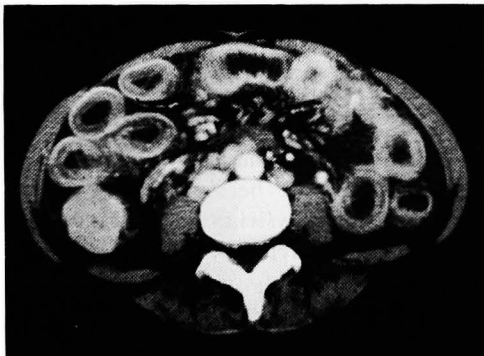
Retention of ascitic fluid and thickening of the intestinal walls were visualized on CT. Contrast effects in the serosa and mucosa were also observed
